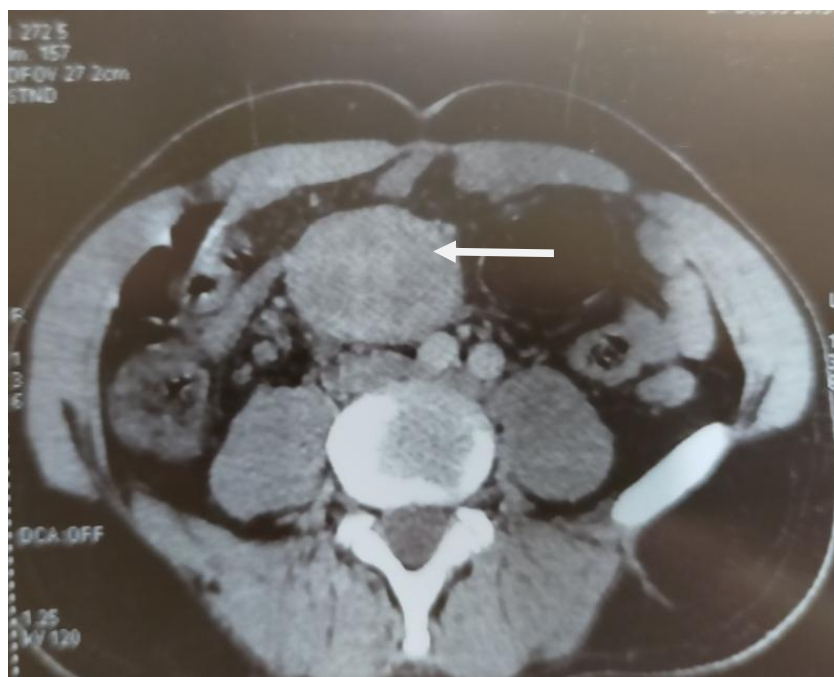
Axial slide of abdominal CT scan showing voluminous mesenteric mass measuring 60*48 mm, containing calcifications and necrosis zone (arrow)
